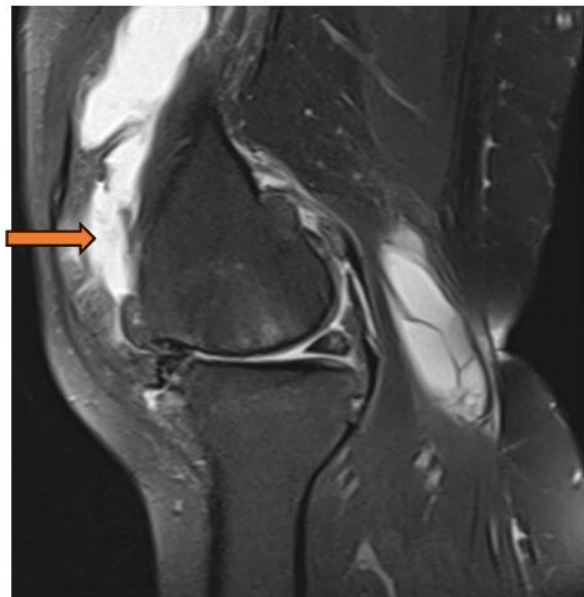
MRI Left knee joint PDFS sagittal section showing supra patellar joint effusion
